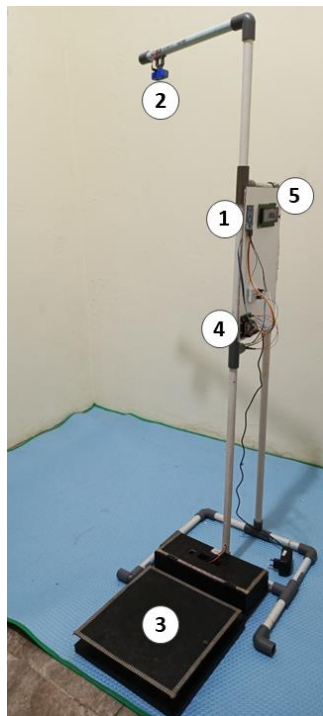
Prototype of the system. Notes: (1) RFID Reader, (2) Ultrasonic sensor, (3) Load Cell sensor, (4) NodeMCU ESP8266, and (5) 20x4 LCD.
